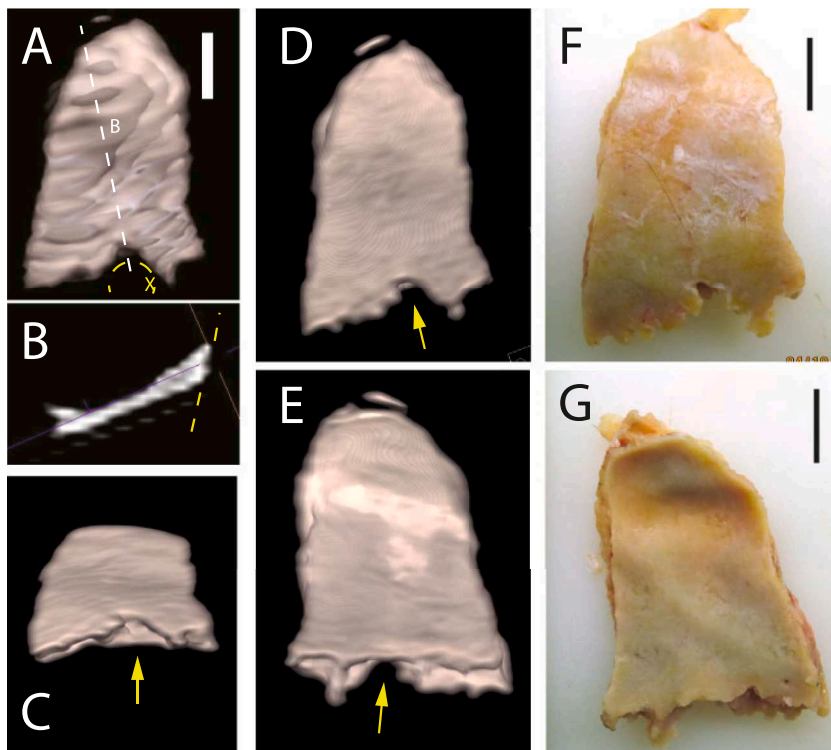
Fragment 1 – On initial whole body PMCT (A), the imaging data of this bone fragment appeared to exhibit a semicircular defect (yellow dashed circle labelled x) that initially seemed possibly consistent with the assumption of a perforating pistol shot injury with outward beveling (B, yellow dashed line, reference to fragment of image B see white dashed line in A). More refined PMCTA reconstructions from same CT raw data (C–E) correlated better with the physical bone fragment margins whereas curvature on outer (D, F) (but not inner, E and G) compact table was that of a ruptured bone suture line. Ultimately, only the photographic appearance of the bone fragment contours allow to understand how the relatively low resolution of the CT images imply what appears to be a semi-circular defect. Bar 10 mm.
